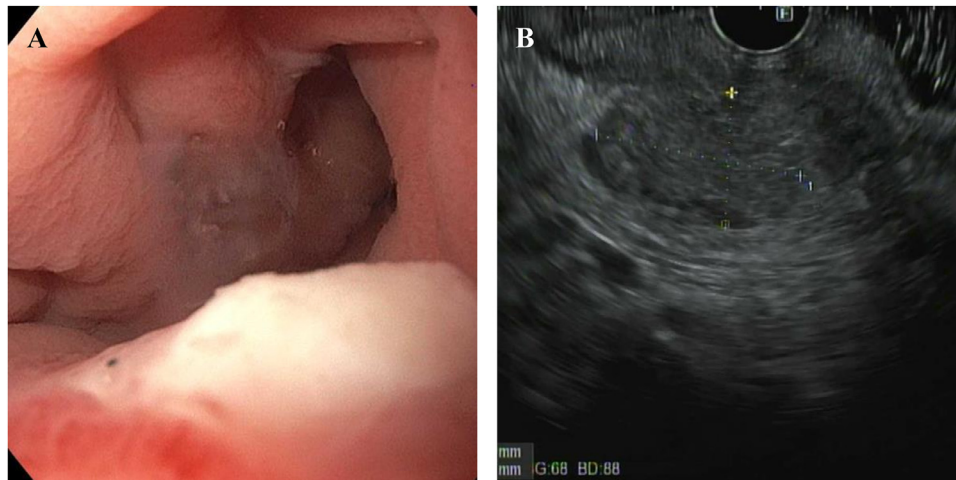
(A) Endoscopic view of an ulcer in the recto-sigmoid colon; (B) Endoscopic ultrasound demonstrating left posterolateral rectal wall noncircumferential lesion within the submucosal layer.
